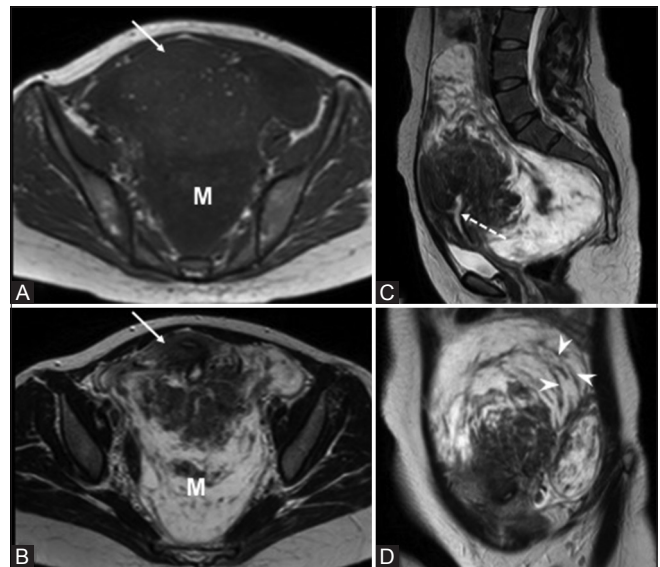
(A-D): (A) On MRI T1 weighted axial section the mass (M) shows roughly two components, isointense to the myometrium with vascular channels closer to the uterine origin (white arrow) and hypointense peripherally. (B-D) MRI T2 weighted images in axial, sagittal and coronal sections. The mass is seen to compress the uterus anteriorly with confirmation of the origin (white dotted arrow in C). Linear hypointense areas are seen within the peripheral hyperintensity corresponding to fibers split up by the edema / fluid accumulation (arrow heads in D)
